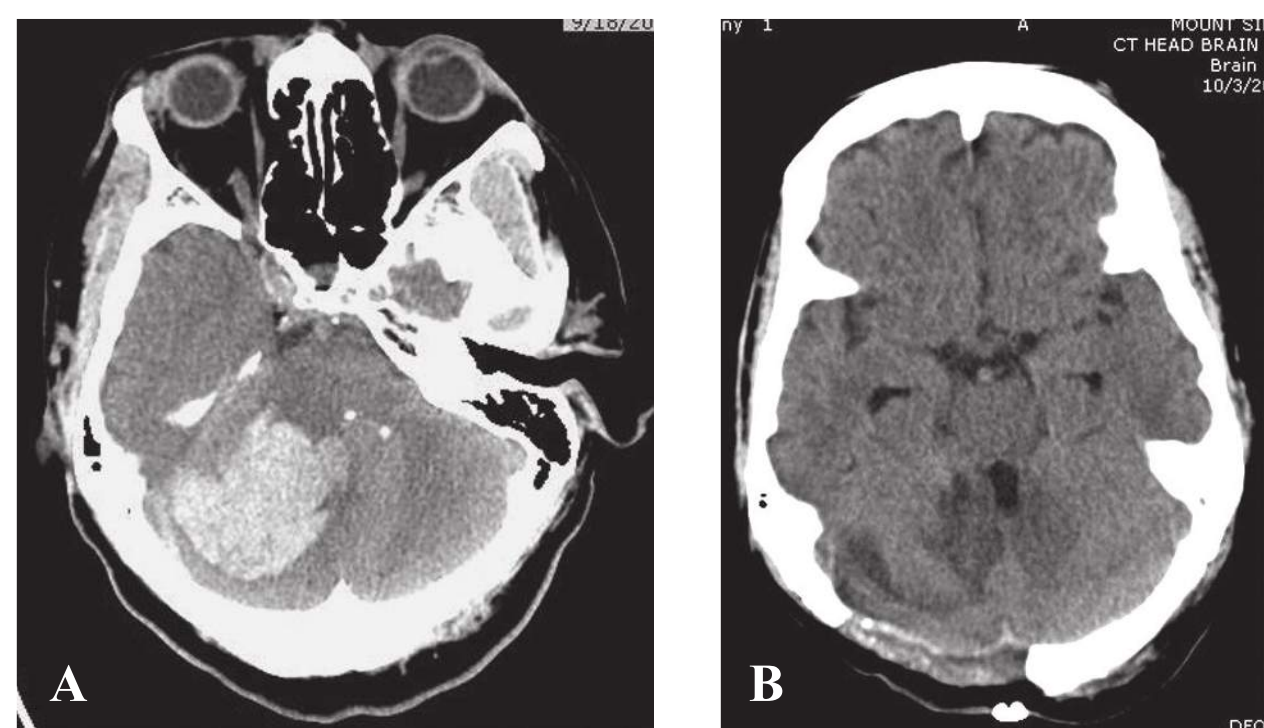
(A and B) Cerebellar hemorrhage and 2 weeks postoperative CT. Note the mass effect that the hematoma causes on the fourth ventricle (fully compressed) and complete effacement of the quadrigeminal plate cistern and brainstem. On the 2-week postdecompressive craniectomy follow-up CT, the fourth ventricle is again visible and the mass effect on the brainstem relieved with residual encephalomalacia in the area of hemorrhage. Immediate relief of the compressive effect of the hematoma is the objective of the surgical intervention.
